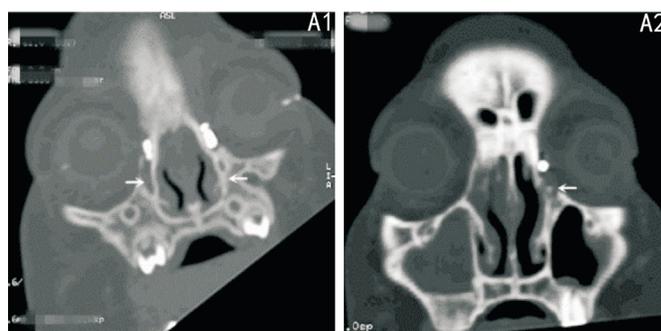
Computed tomography dacryocystography of proband and the patient (III:1) in the family in our study A1: Note congenital nasolacrimal duct obstruction in the both eyes of proband (III:2); A2: Note congenital nasolacrimal duct obstruction in the left eye of the patient (III:1).
